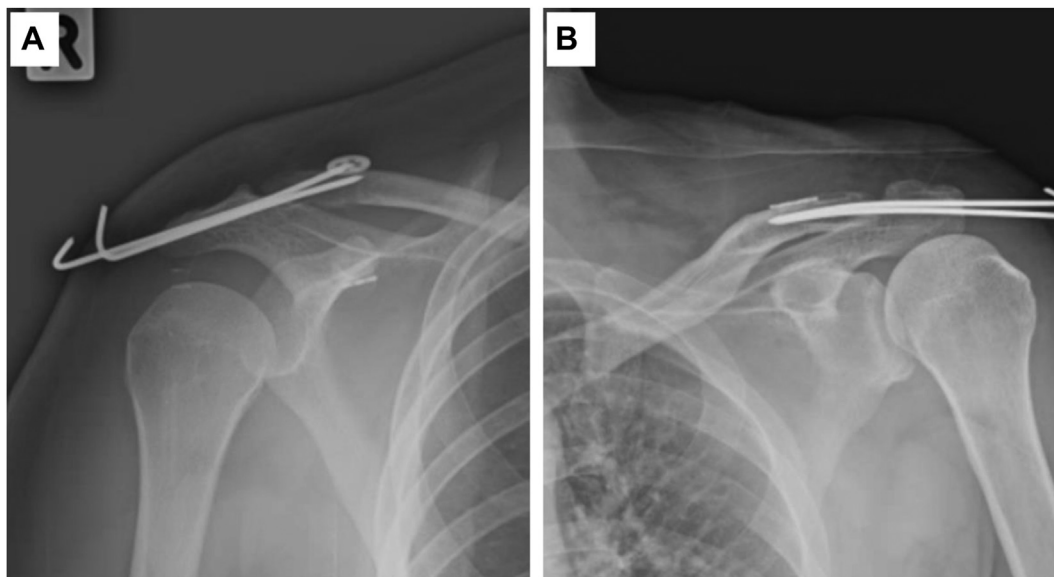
The Zanca radiograph of the shoulders. (A) A Single coracoid and clavicular tunnel technique of the right shoulder. (B) Coracoid loop around the clavicle with 2 clavicular tunnels.
